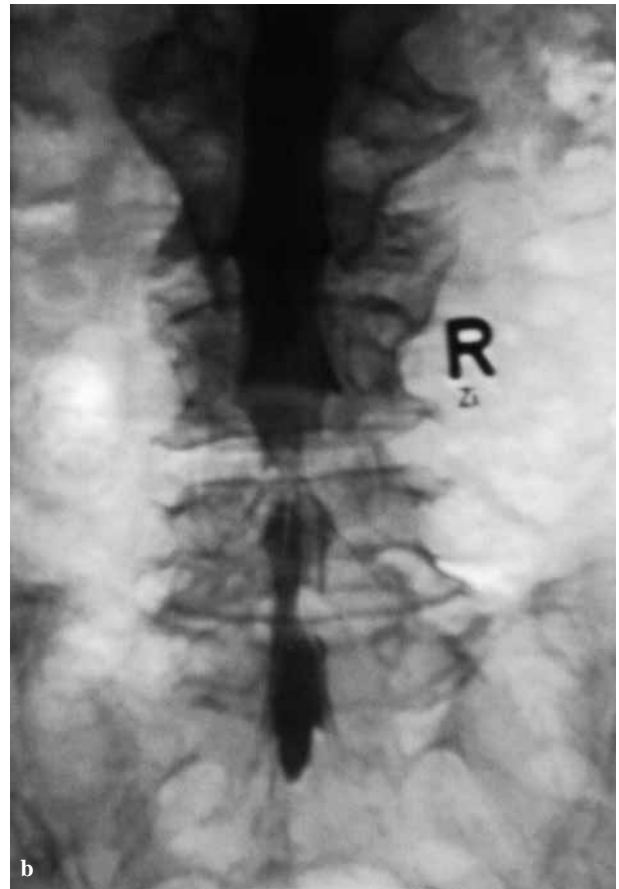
Myelogram and MRI of moderate stenosis.
